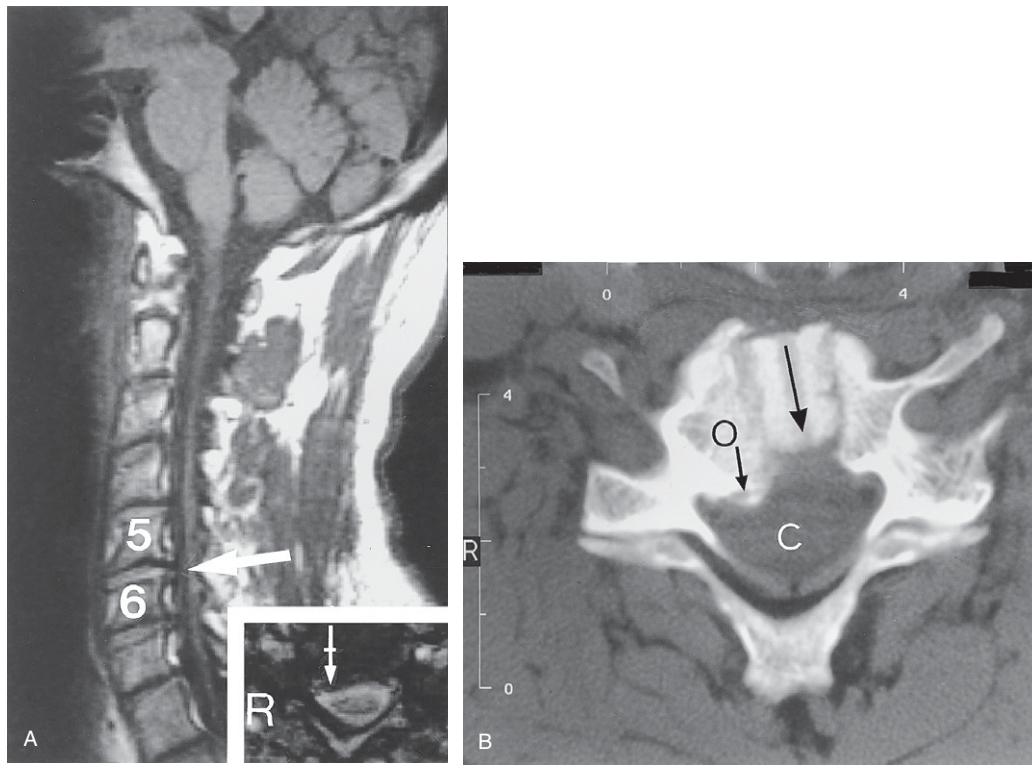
(A) Cervical spine MRI parasagittal T1-weighted image showing osteophyte/disc protrusion at C5–6 (white arrow). This right-sided posterolateral disc protrusion is shown in the axial insert (tailed arrow). R = right side of patient. The MRI report read: There is some osteophyte/disc distortion of the cord at C5–6 level. Disc protrusion extends into the intervertebral foramen. There also appears to be a right-sided posterolateral osteophyte at C6–7 but it does not impinge upon the right intervertebral foramen. (B and C) Cervical spine CT axial image of the C5–6 level following the Cloward procedure (performed 3 months previously) to remove the right sided posterolateral disc protrusion and osteophyte seen by MRI as being present at C5–6. Note that the *left* side was decompressed instead of the right side which still shows the disc osteophyte (O) complex on the patient's right side (R); this compresses the anterolateral portion of the dural tube. The surgical approach (large black arrow) was directed to the patient's left side. C = spinal cord within the spinal canal.
